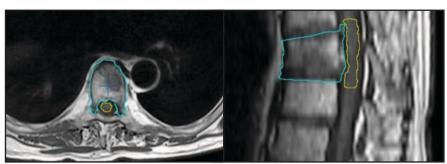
The CTV and cord are delineated with high-definition MRI.
